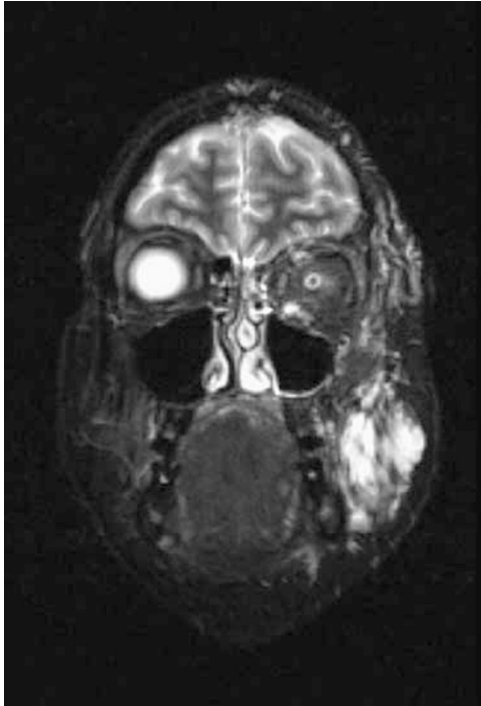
Coronal STIR MRI sequence showing the lymphatic-venous malformation as areas of abnormal high signal centred within the left masseter and extending superiorly to involve the temporalis and inferior rectus muscles. The left superior ophthalmic vein is enlarged.
